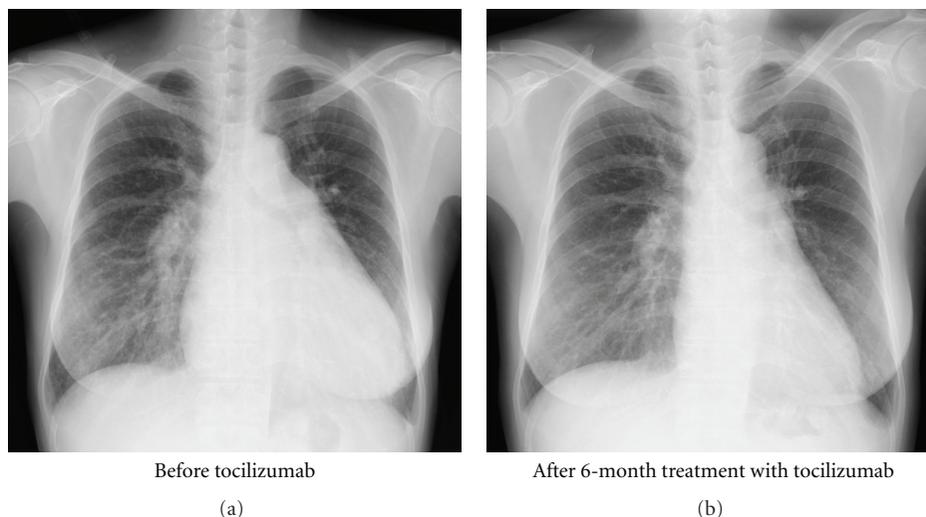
Chest X-ray before tocilizumab and after 6-month treatment with tocilizumab.
